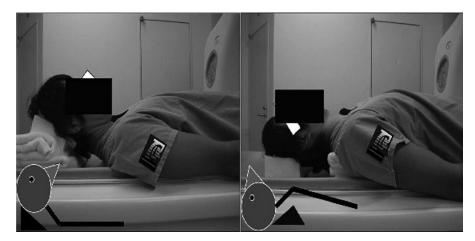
Supine position of dynamic multidetector-row computed tomography. Computed tomography scans during maximum flexion (Left) and extension (Right) after myelography. The pillow was under the head during flexion and under the higher back during extension. The height of the pillow was adjusted to each patient.
